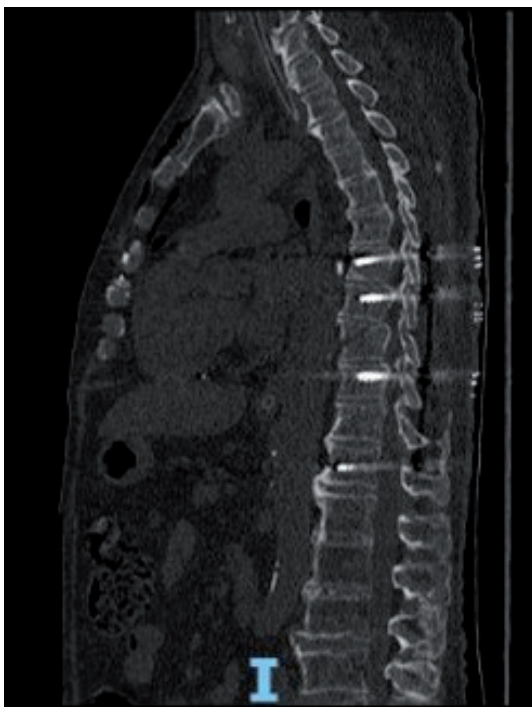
X-ray after surgery with 5 segments fixation.
